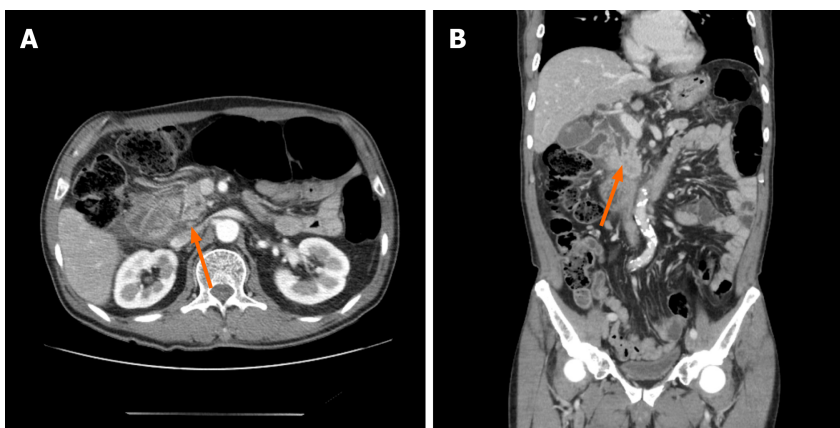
Computed tomography of the abdomen two days after endoscopic ultrasound-guided tissue sampling. A and B: Edematous wall thickening of the second portion of the duodenum with adjacent fluid collection was detected and a leak was suspected (orange arrows).
